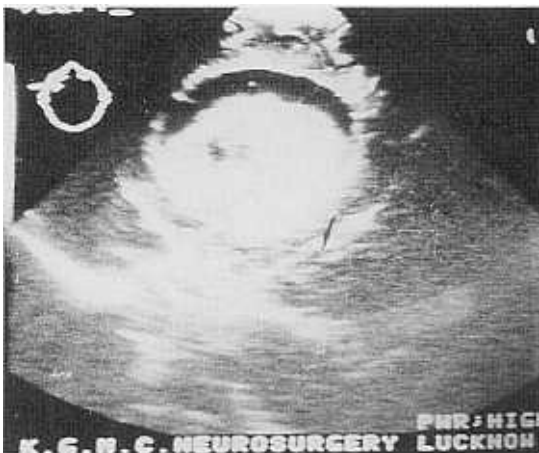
Intraoperative ultrasonogram (A) anterior portion, (B) posterior portion showing well defined mass with multiple hypoechoic areas.
